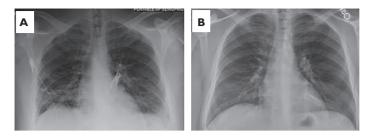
Chest X-ray 72 hours after initiation of high dose steroid therapy on the day of discharge demonstrated a significant improvement (A). A followup X-ray one week after discharge was normal (B).
